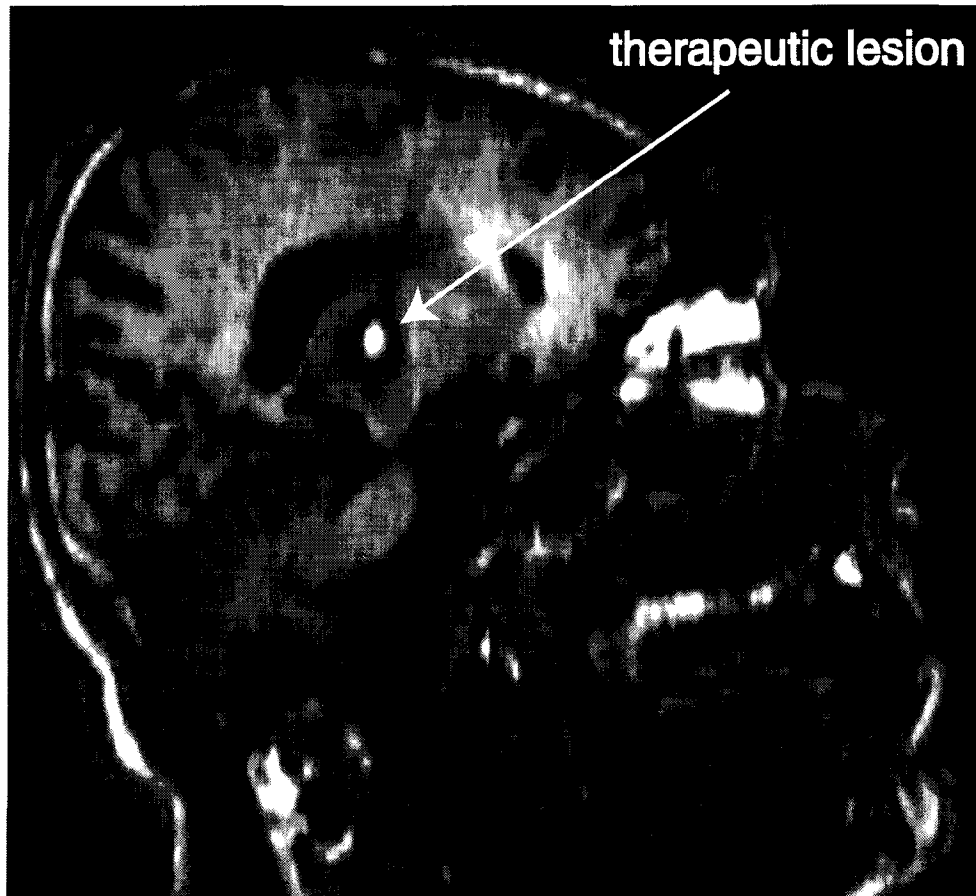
Sagittal MRI section showing hyper-intense post-operative lesion.
